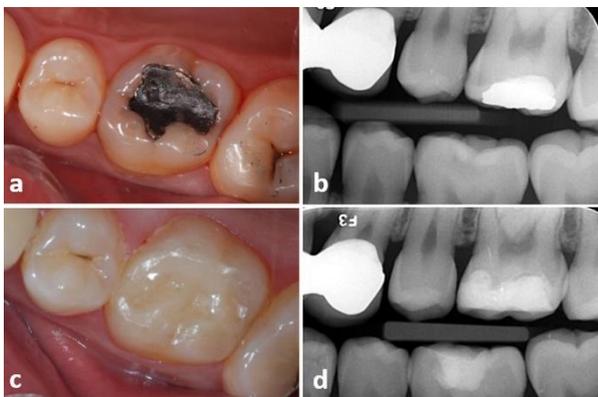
(a) A maxillary left first molar, with caries recurrence on an occlusal amalgam restoration (b) Bite-wing radiograph of the maxillary left first molar (c) 1 year follow-up of cerasmart indirect restoration (d) Bite-wing radiography of cerasmart indirect restoration
